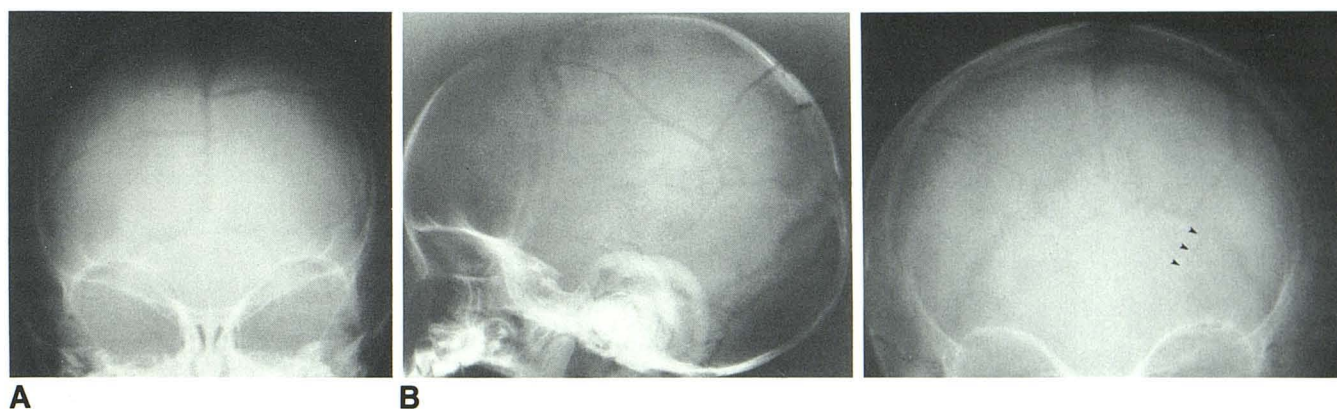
8-month-old abused boy. Anteroposterior (A) and lateral (B) skull radiographs reveal multiple, bilateral parietal fractures.
